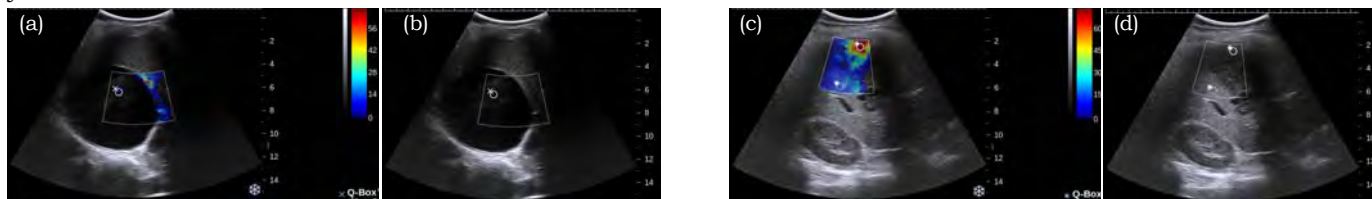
Large recurrent cyst of the right adrenal gland with elasticity imaging (a) and B-mode ultrasound (b). Cyst does not show elasticity signal as shear waves do not propagate through liquids. Some denser material inside the cyst shows soft elasticity signal of 5 kPa.
